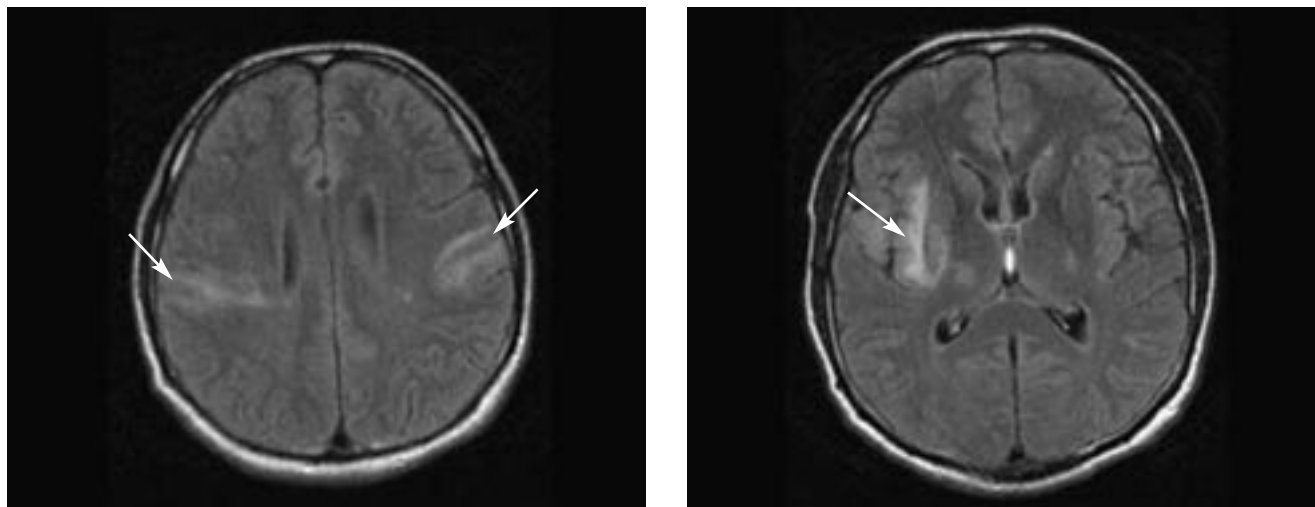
Magnetic resonance images with fluid-attenuated inversion recovery (FLAIR) showing bilateral regions of hyperintensity (arrows).
